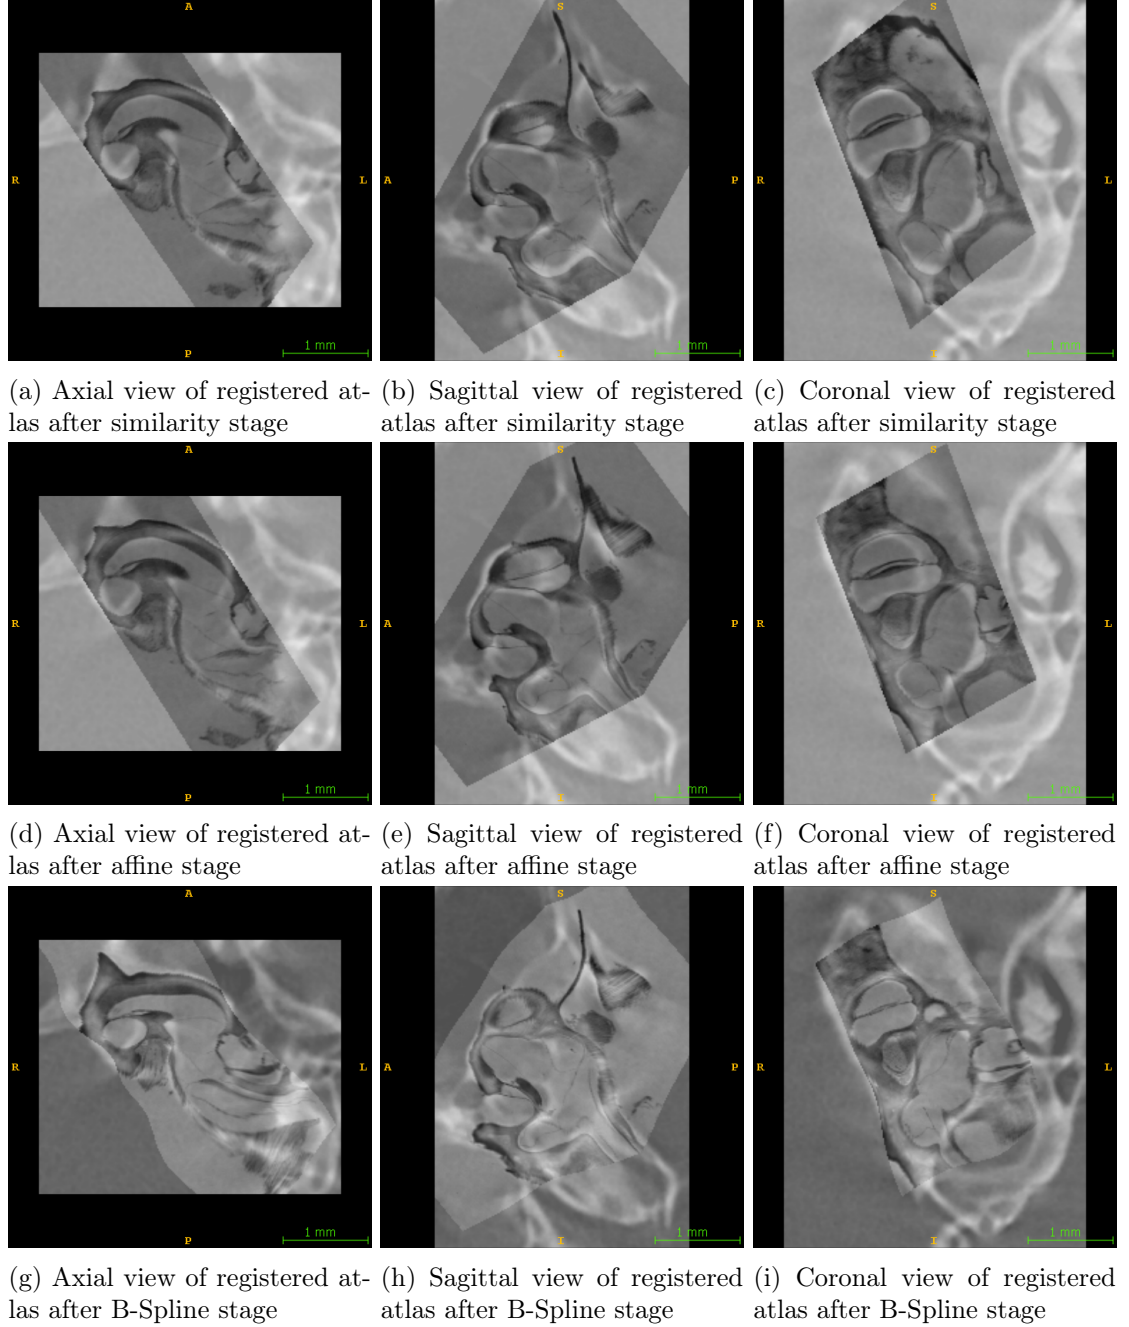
Three orthogonal 2D views of the overlapping between registered atlas image of each stage and the μ CT images of scan #1. Different stages are represented in different rows. The left column are axial views, the center column are sagittal views and the right column are coronal views.
